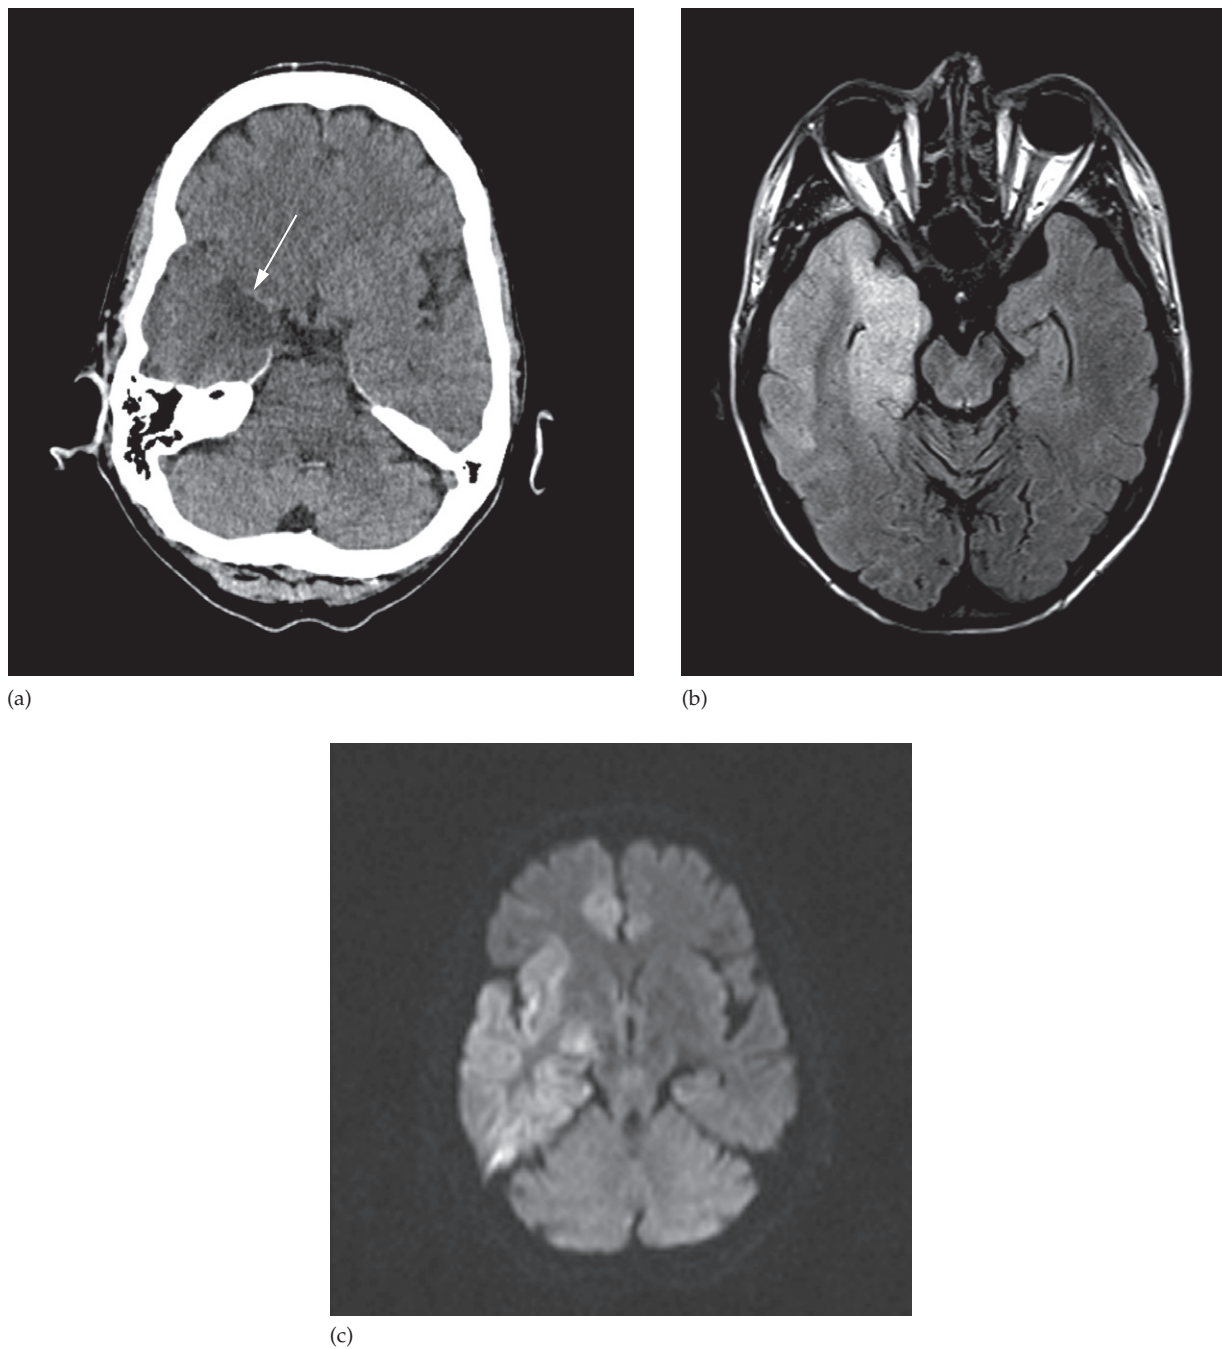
Acute viral encephalitis. (a) Unenhanced CT showing low density in the right temporal lobe (arrow) in a distribution unusual for an acute infarct. (b) Axial FLAIR sequence showing high signal oedema and swelling in the medial temporal lobe and hippocampus. (c) DWI showing acute restricted diffusion of acute encephalitis in the right temporal lobe and inferior frontal lobe.
